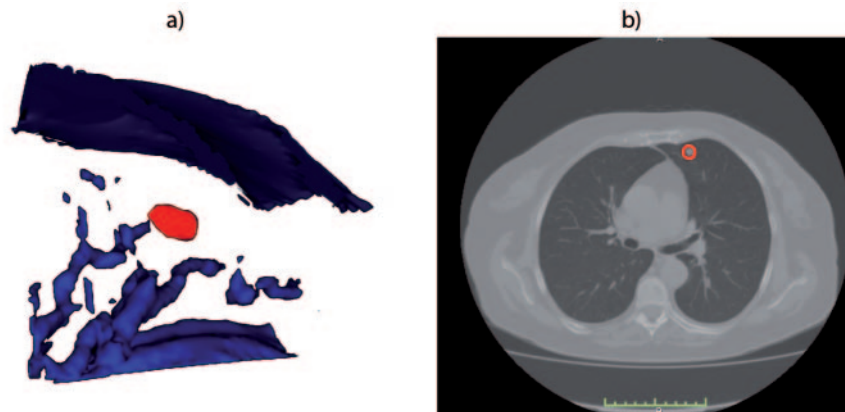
(Colour online) Pictures representing an internal nodule. a) Rendering of the internal part of a lung, in red is shown an internal nodule. b) A CT image containing an internal nodule.
